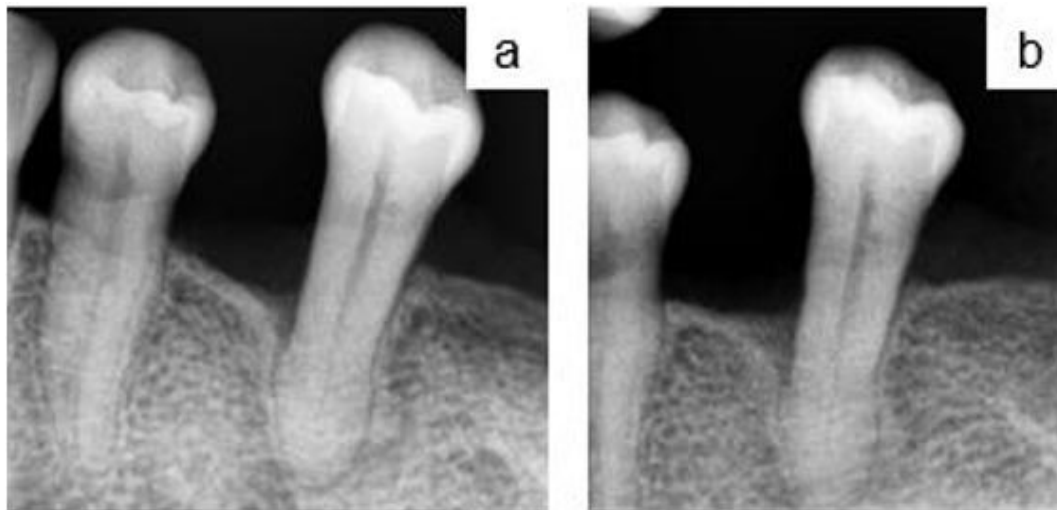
Periapical radiograph on lower left second premolar at (a) 15 months of review; (b) 22 months of review
